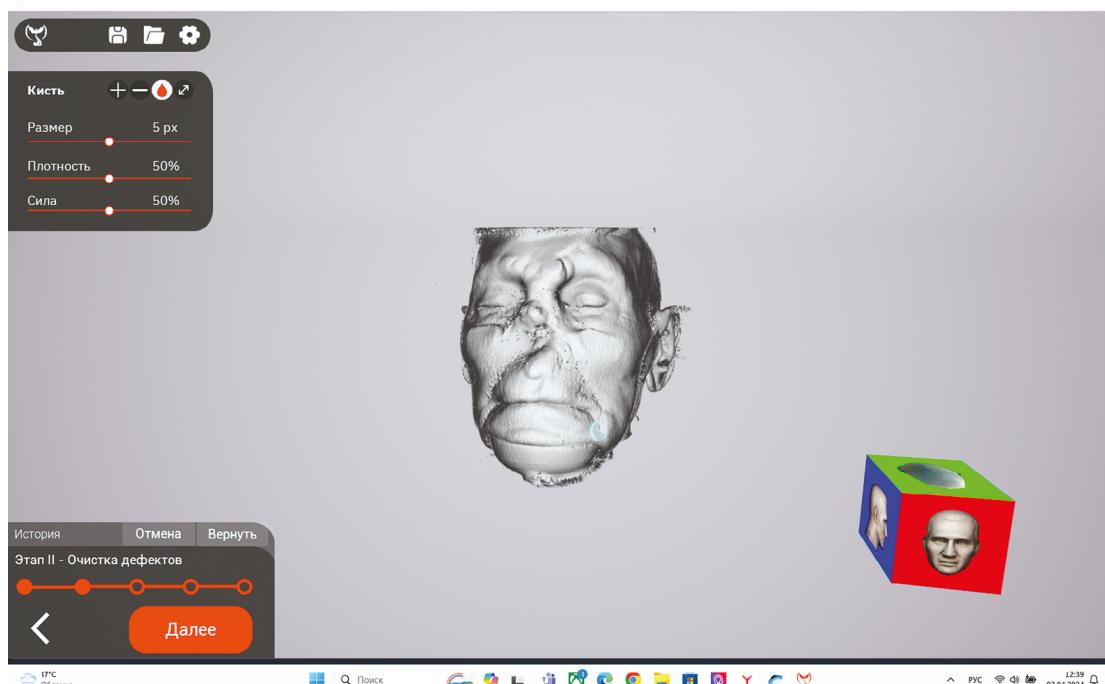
Conversion of computed tomography data into .stl format in the developed program.
